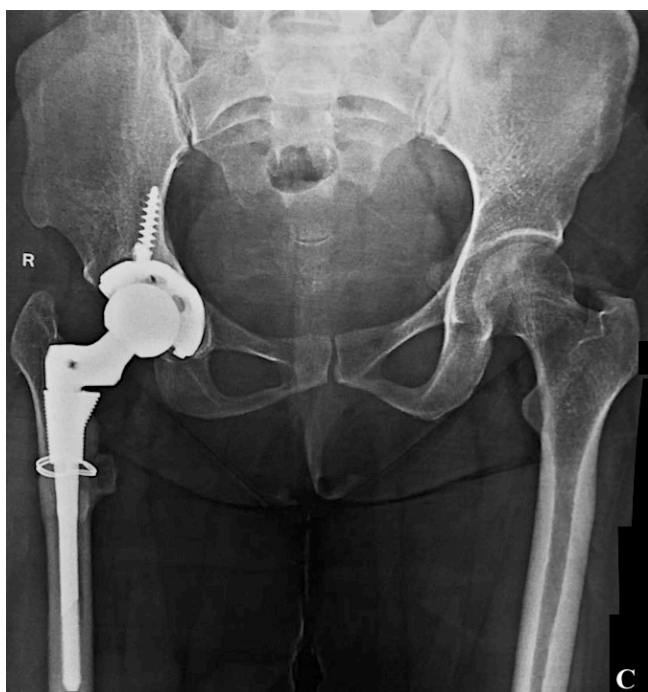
Five years follow up X-ray of pelvis with both hips showing stable implants in right hip. The osteotomy site is united.
